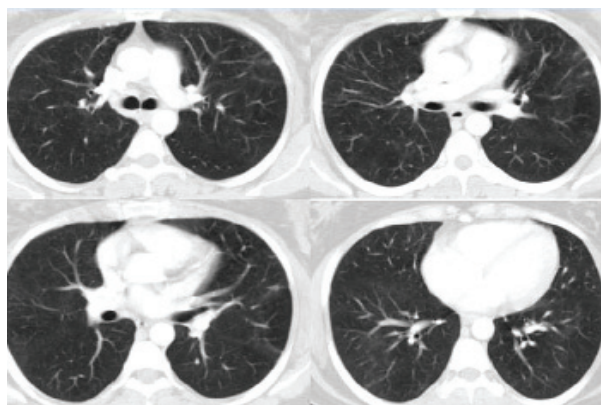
CT scan on control after four-week
